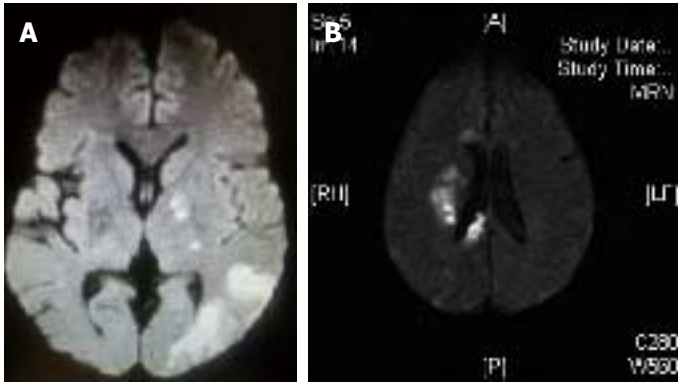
Magnetic resonance imaging diffusion-weighted images of different lesion patterns. A: Concomitant perforating artery infarct and pial infarcts; B: Border zone infarcts.
